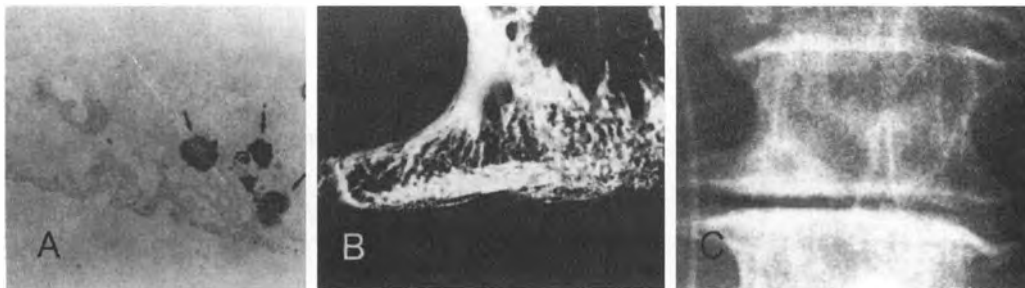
Superior surface of L4 in an 82-year-old man. A and B. Small projections of subchondral bone into the cartilaginous end plate can be observed (*arrows*). C. Radiograph shows completely normal appearance of the end plate. (Reprinted with permission from Aoki J, et al. End plate of the discovertebral joint: degenerative change in the elderly adult. *Radiology* 1987;164(2):412.)
